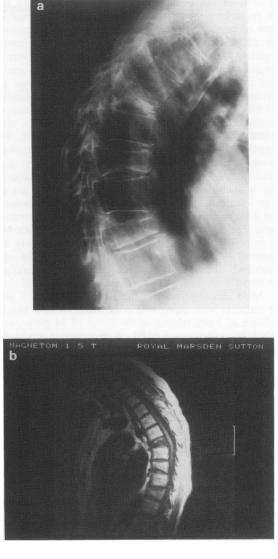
a, Lateral plain radiograph of the thoracic spine demonstrates anterior wedging of the vertebral bodies of  $T_7$ ,  $T_9$  and  $T_{11}$ . 2b, The corresponding sagittal  $T_1$  weighted (TR 50 msec TE 17 msec) MR image of the thoracic spine shows low signal intensity within the vertebral body of  $T_7$  consistent with replacement of the normal fatty marrow by malignancy infiltrate. There is preservation of the normal high signal intensity of the marrow with  $T_9$  and  $T_{11}$  consistent with osteoporotic collapse.
